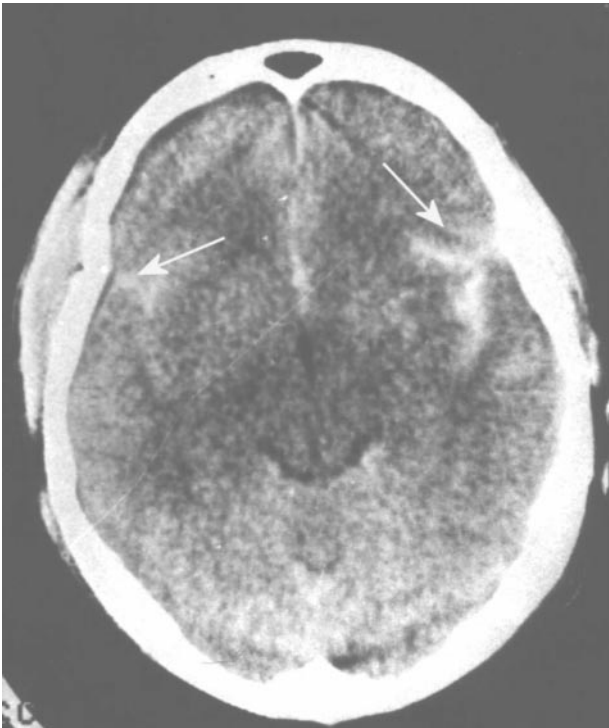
CT subarachnoid hemorrhage-diffuse hyperintense areas predominantly on the sulci
